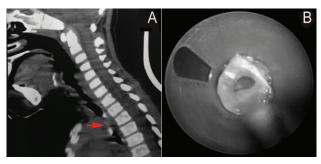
A: Contrast-enhanced computed tomography of the neck revealing narrowing of the tracheal lumen by a soft tissue swelling in the subglottic region. B: Tracheal pseudomembrane visualized during rigid bronchoscopy causing 80% occlusion of the tracheal lumen.
